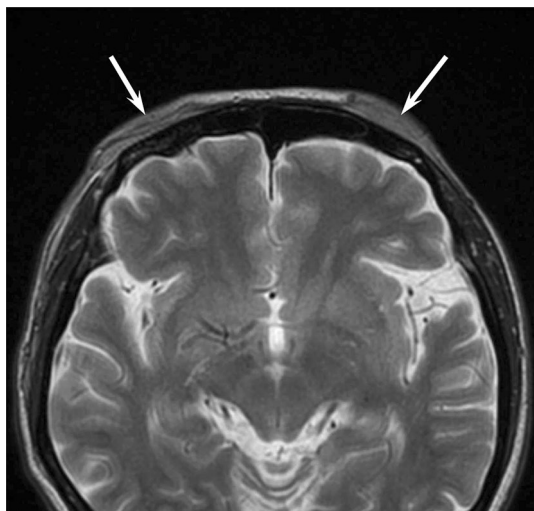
A 52-year-old woman with mucosa-associated lymphoid tissue lymphoma. T2-weighted image shows a homogeneously isointense subcutaneous lesions (arrows)
